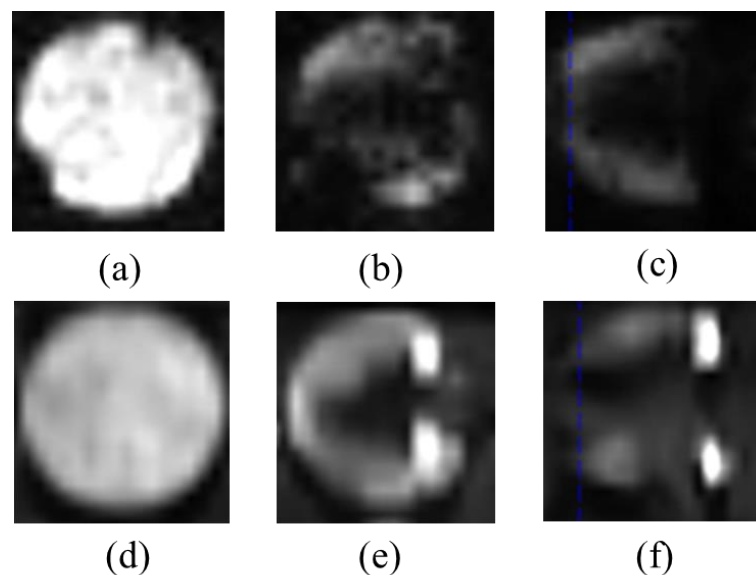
MRI images of Iron NPs/PNIPAM system.
